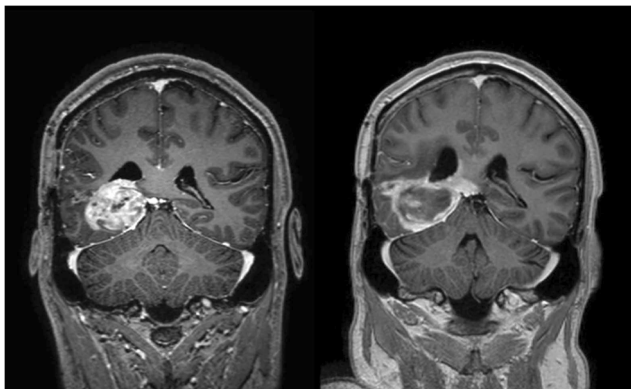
MR images before and after 10 days of treatment in patient 5. Extensive necrosis in previous contrast enhancing tumor tissue is demonstrated
